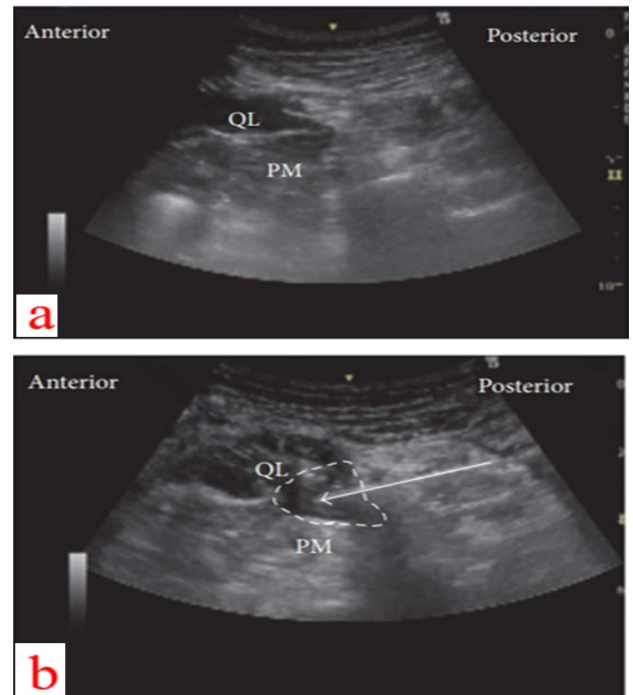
Ultrasonic images of the anterior QLB. (A) pre- and (B) post-injections are both included. QL is for the quadratus lumborum, PM stands for the psoas muscle, the white arrow represents the needle trajectory, and the white dotted line represents the spread of the local anaesthetic. [21]
